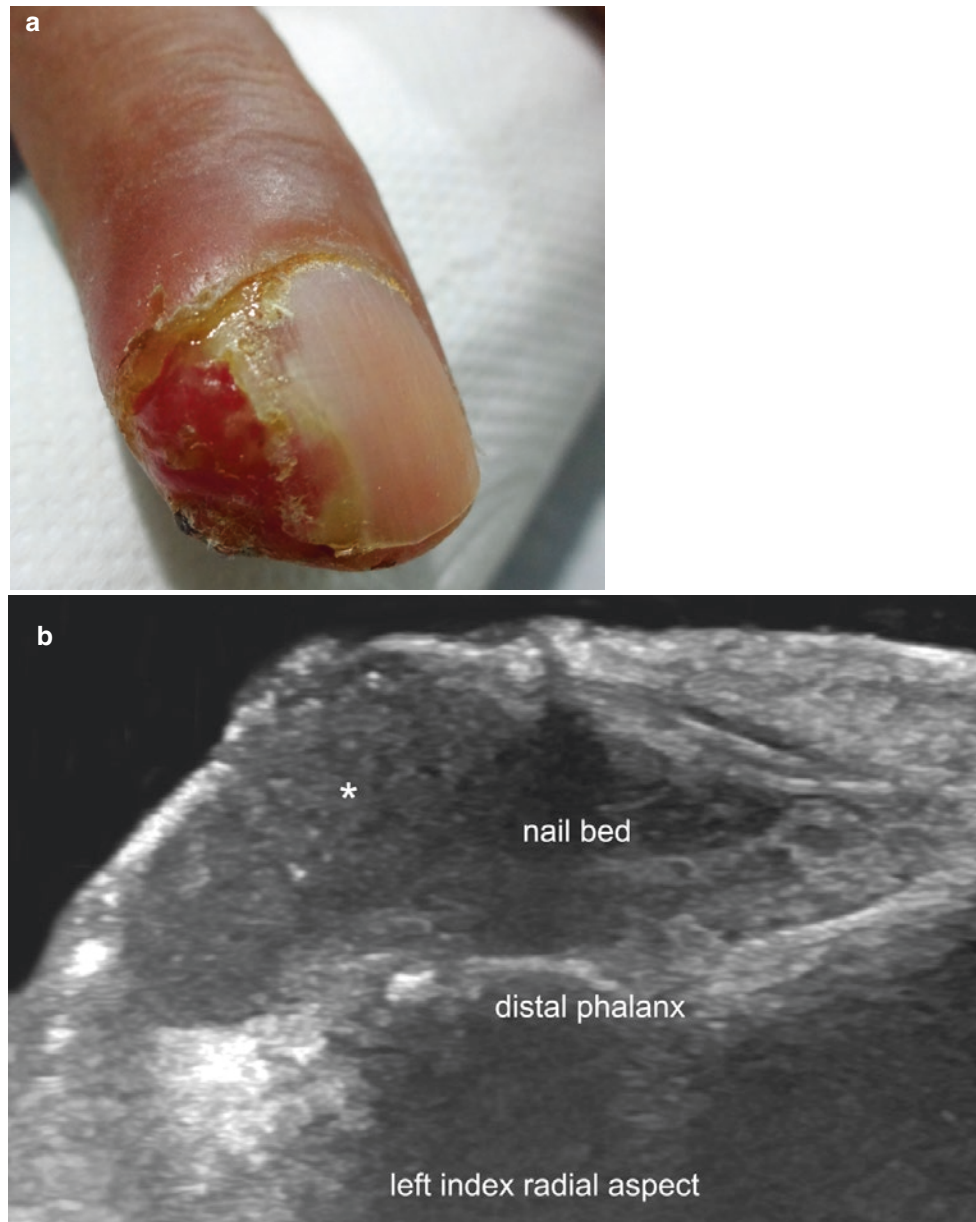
Squamous cell carcinoma. (a) Clinical image of the nail of the left index finger. (b–d) Ultrasound images (b, greyscale; c, power Doppler, longitudinal views; and d, color Doppler, transverse view) demonstrate an ill-defined, eccentric, hypoechoic mass (*asterisk*) that
